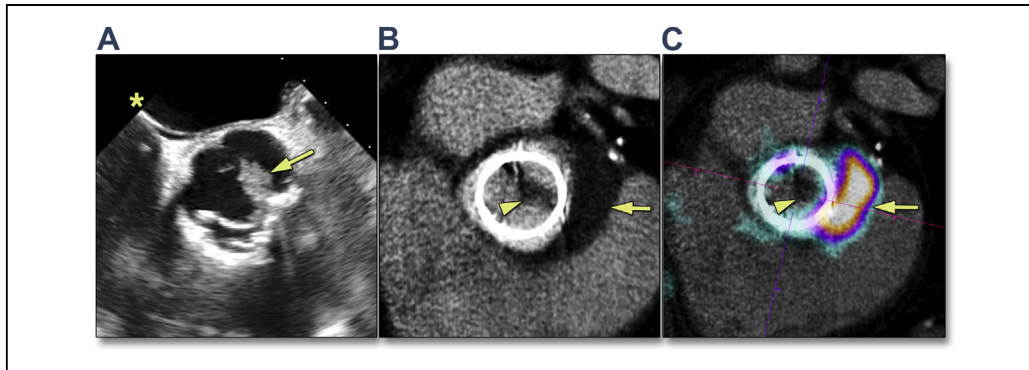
Combined CTA and FDG/PET Imaging Detects Both Vegetations and Periannular Extensions
